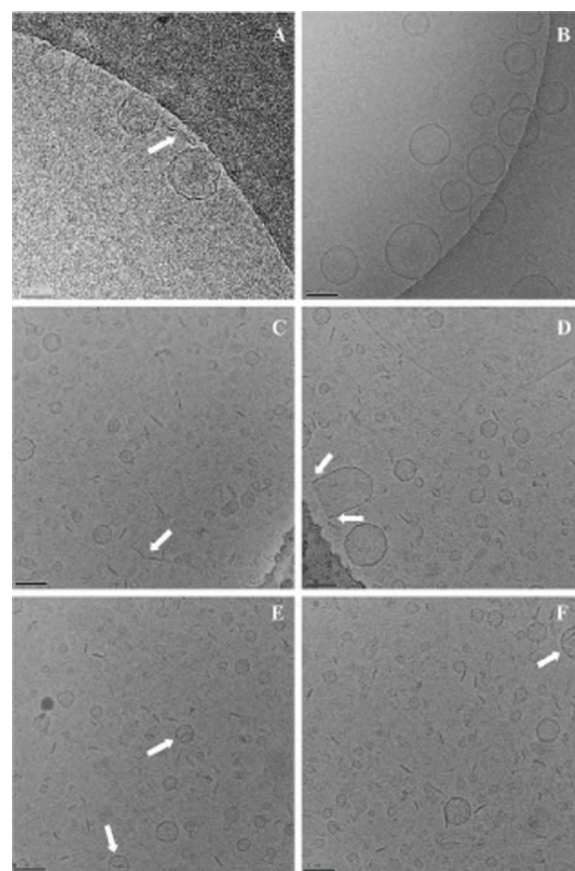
Cryo-TEM images of (A) DPPC MLV after 20 min of FUS (B) DPPC MLV passed through polycarbonate filters of 200 nm pore; (C–F) DPPC/LysoPC/DSPE-PEG-2000 MLV after 20 min FUS. Reprinted with permission from [47], Tejera-Garcia, R., et al., 2011. Making unilamellar liposomes using focused ultrasound. *Langmuir*, 27(16), pp.10088–10097. Copyright@American Chemical Society.
